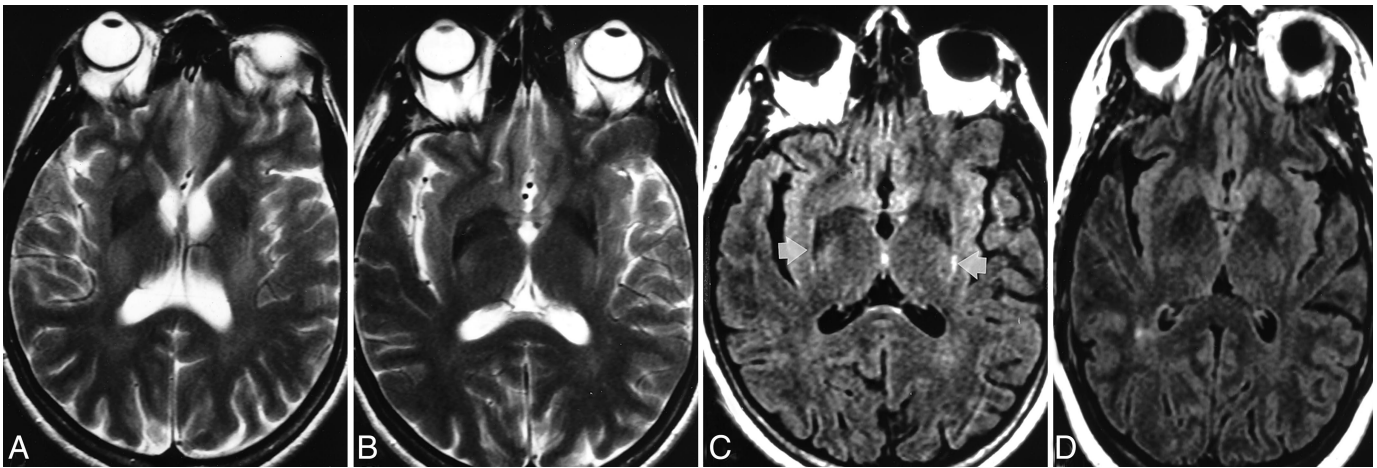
Axial T2 (A–B) and fluid attenuated inversion recovery (FLAIR) (C–D) MRI, performed as detailed.<sup>2</sup> The patient (A–C) has posterior/lateral putamen hypointensity (iron deposition) (A–B). The patient's FLAIR (C) shows linear lateral putamen hyperintensities (arrows), seen better on FLAIR than on T2 (B). Such hyperintensities are absent on FLAIR from an age-matched, healthy control (D).
